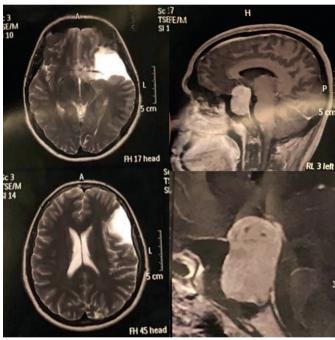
Magnetic resonance imaging of the skull with emphasis on sella turcica: intra and suprasellar lesion (4.0 x 3.0 x 2.5 cm) , it encompasses the intracavernous segment of the internal carotid arteries, compression and cephalic displacement of the optic chiasm. Cystic lesion in the left middle fossa (8.0 x 5.0 x 4.8 cm) with mass effect and slight displacement of the midline to the right, associated with hypoplasia of the left temporal lobe.
